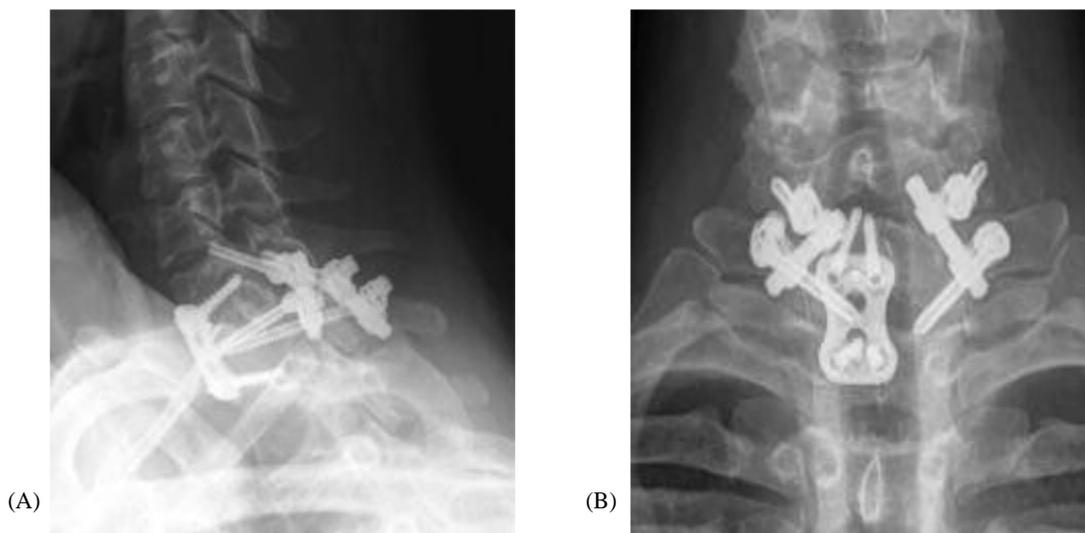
Postoperative X-ray lateral (A) and AP (B) views after reduction of case showed in figure 10, combined fusion and insertion of a tricortical bone graft into the disc space C7-T1.
